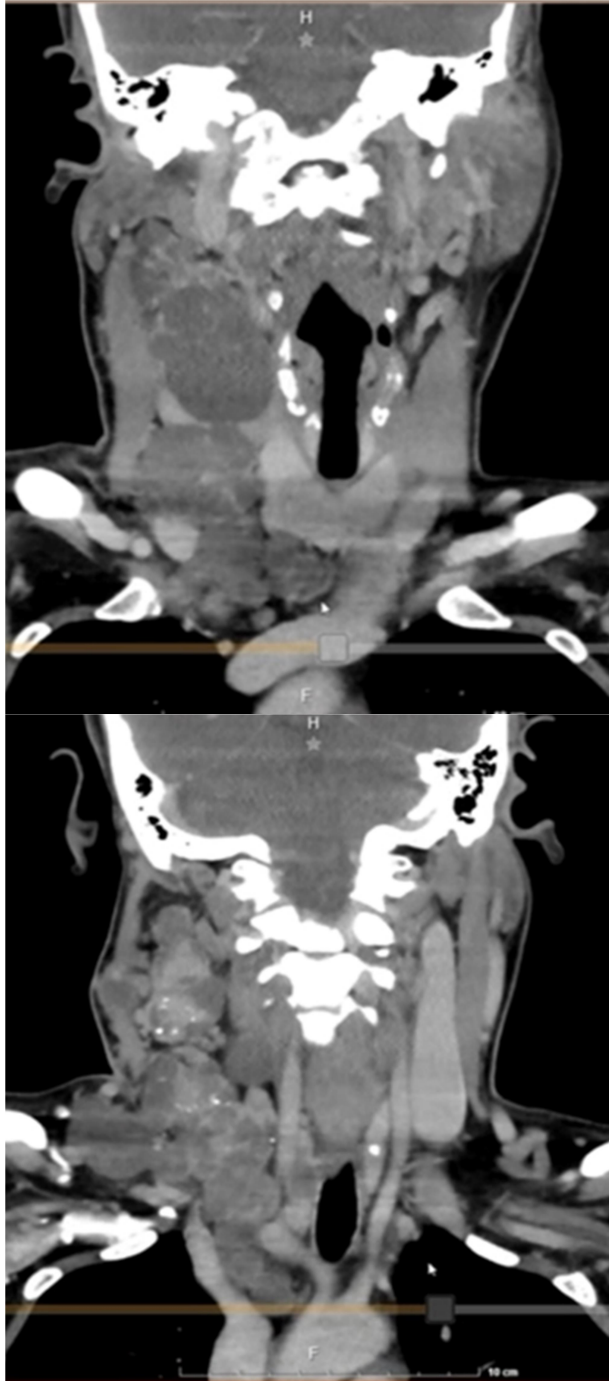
A short coronal CT scan of the neck shows a heterogeneous hyperdense with multiple hypodense areas due to probable central necrosis extending from zones II and III of the neck at the level of the right internal jugular chain, infiltrating the sternocleidomastoid muscle, lesion of similar characteristics to the previous one described at level IV with intrathoracic extension, and another significant lesion at level VII in the anterior mediastinum.
